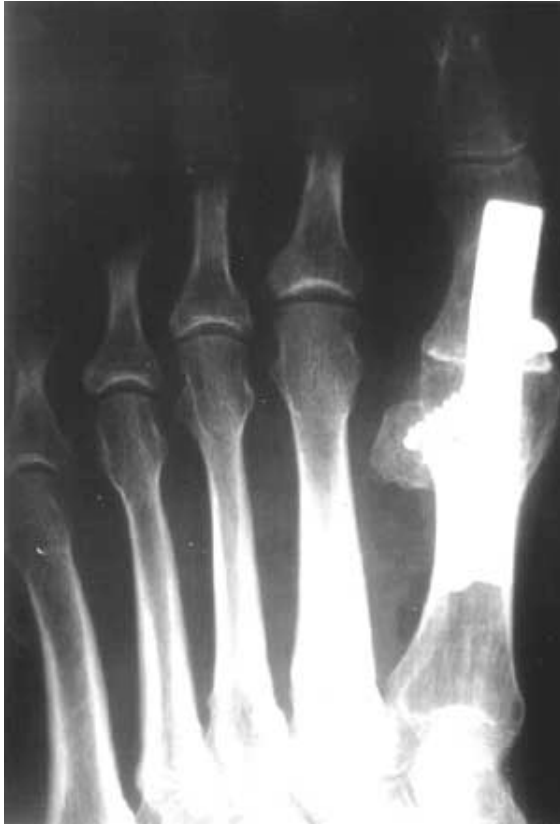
Postoperative radiograph of arthrodesis with dorsal plate fixation. a) dorsoplantar radiograph.
